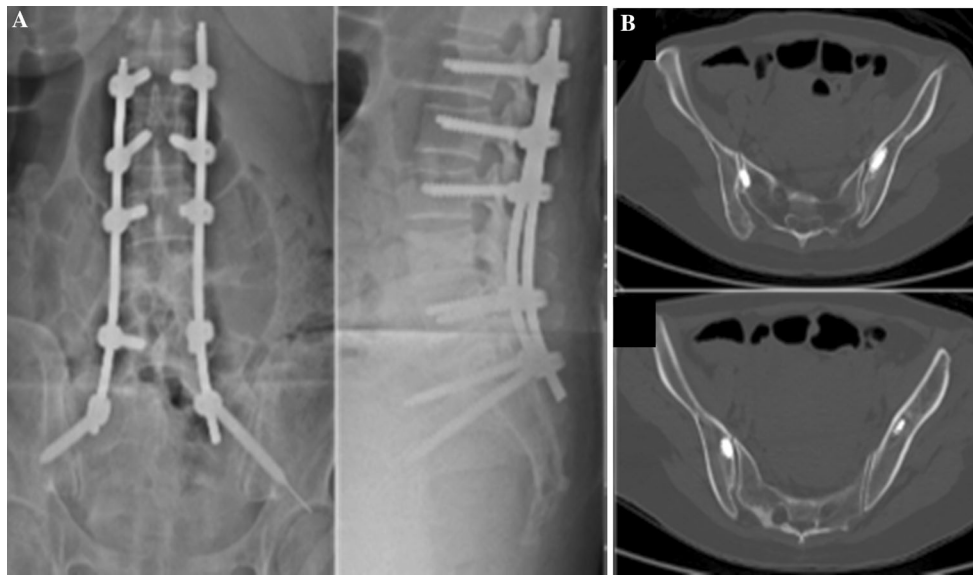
Patient B had underlying metastatic uterine cancer and presented with a pathological L4 fracture. Post-op radiographs (a) and axial CT images (b) showing MIS L1, L2, L3, L5 and iliac instrumentation
